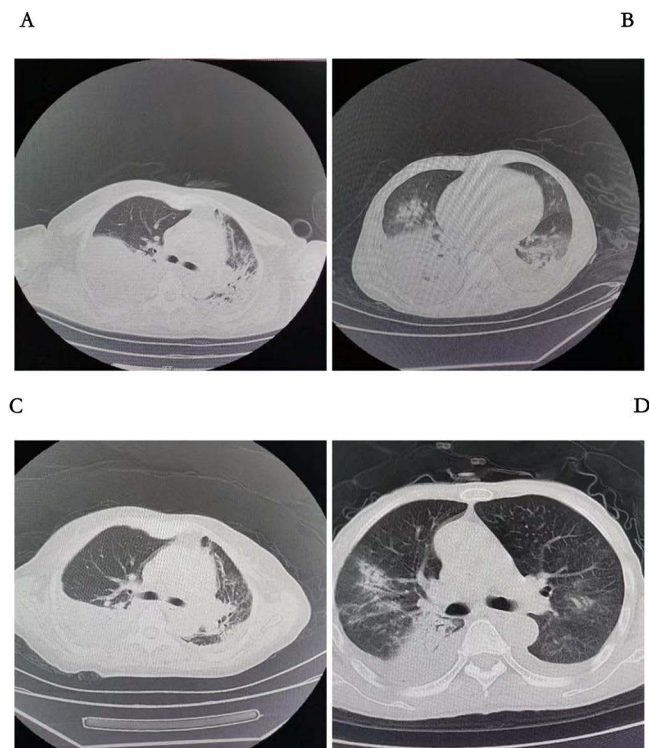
Computed tomographic images from a 54-year-old woman (A and B) and a 78-year-old man (C and D) A, Image obtained on day 1 hospital. B, Image obtained on day 13 hospital. C, Image obtained on day 1 hospital. D, Image obtained on day 7 hospital.
